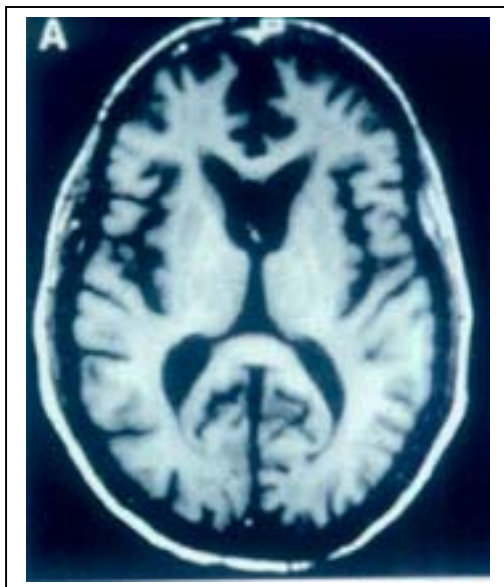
Progressive changes in the white matter on T-2 weighted MRI scans in a patient with HIVD taken 6 months apart
